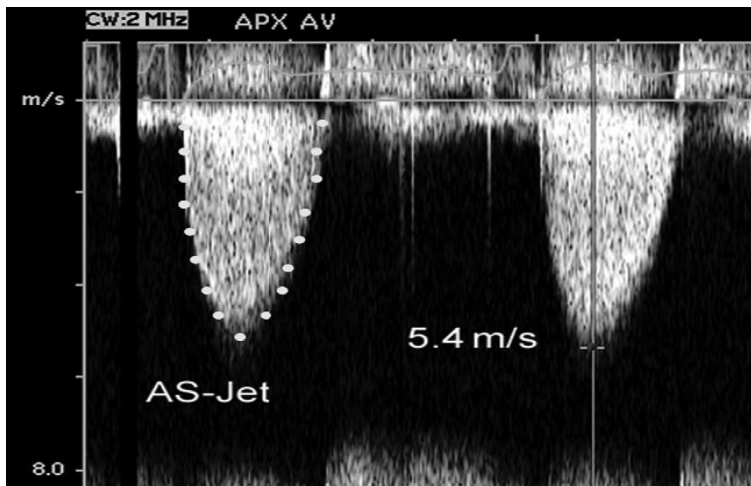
Continuous-wave Doppler of severe AS jet (70)
